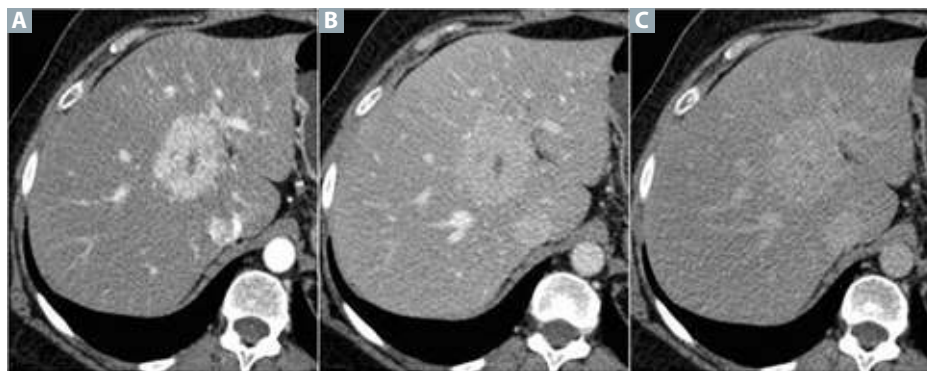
Contrast-enhanced arterial phase CT scan of focal nodular hyperplasia (FNH). (A) an axial view of the liver with FNH is seen during the arterial phase of contrast administration. (B), the portal phase is seen of this same liver lesions demonstrating washout (loss of brightness) of this lesion. (C) delayed imaging (taken after the portal venous phase) revealing further washout of the liver lesion. All three images reveal a hypodense, central, stellate-shaped region in this lesion. (Adapted with permission from Scialpi M, Pierotti L, Gravante S, et al. Split-bolus versus triphasic multidetector-row computed tomography technique in the diagnosis of hepatic focal nodular hyperplasia: A case report. *J Med Case Rep.* 2014;8:425.)
